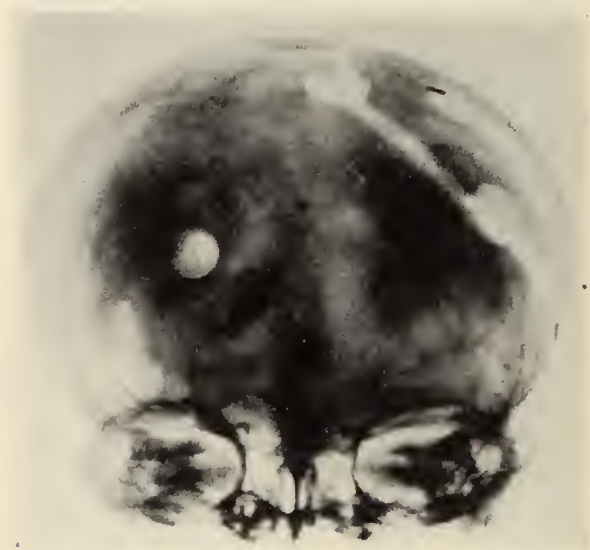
Postoperative x-ray showing calcifications remaining in right lateral and third ventricles
